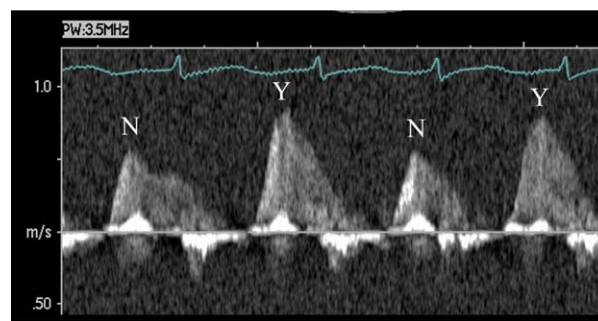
Pulsed-Doppler ultrasound of the left anterior descending coronary artery in a patient treated early after coronary surgery with 2:1 aortic counterpulsation shows a 25% increase in coronary flow velocity in the assisted (Y) compared to the non-assisted (N) beats.
